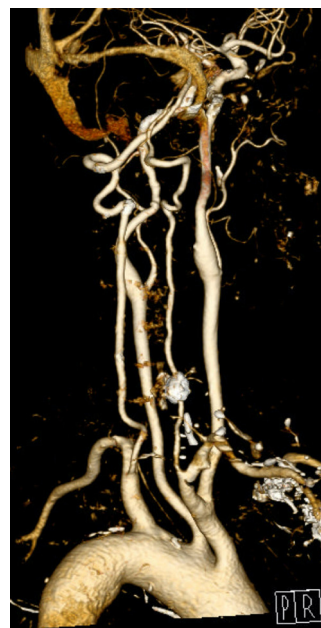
Since the procedure, the patient has been in clinical follow-ups through outpatient department, and neck carotid computed tomographic angiography performed after 24 months showed no signs of fistula recurrence.
